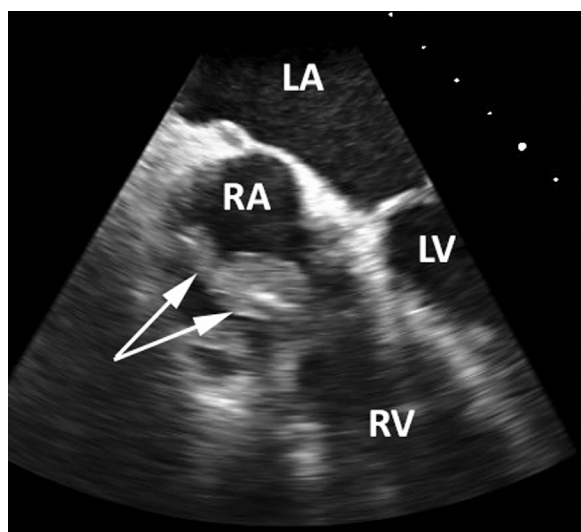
Transesophageal echocardiography showing a large vegetation (arrows) measuring 46 25 mm attached to the implantable cardioverter-defibrillator right ventricular lead at the level of the tricuspid valve. LA = left atrium; LV = left ventricle; RA = right atrium; RV = right ventricle.
